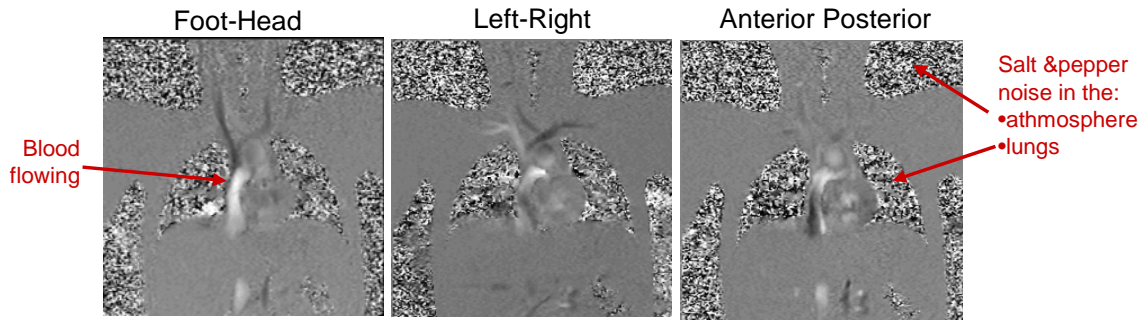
Example of a 3D PC MRI acquisition. All three images are acquired in the same plane, but with the velocity encoded in three orthogonal directions, namely in the Foot-Head, Left-Right, and Anterior-Posterior directions.
